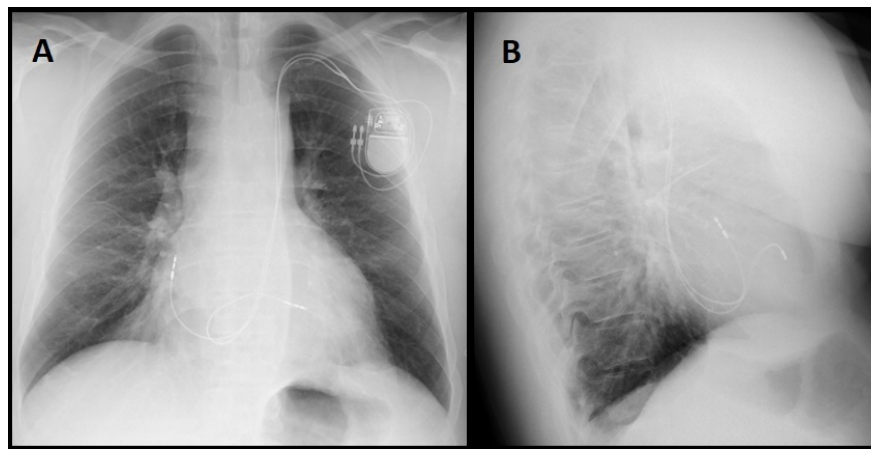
Chest X-ray 3 months postimplantation (A: posteroanterior view; B: lateral view), with ventricular lead in the the left bundle branch area, and the atrial lead in the right appendage.
